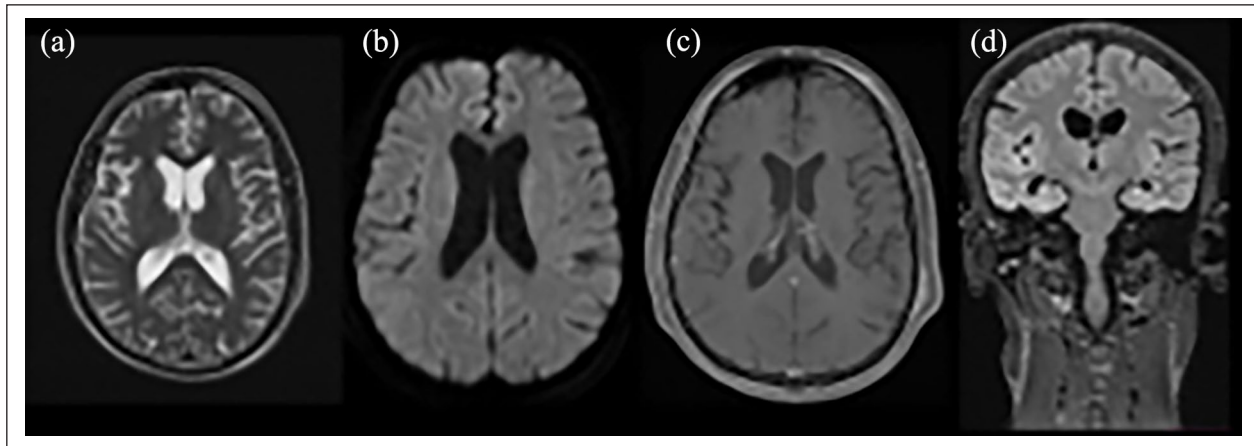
One-month follow-up magnetic resonance imaging on axial T2: (a) Diffusion-weighted imaging, (b) T1 post-gadolinium injection, (c) axial images and coronal T2 fluid-attenuated inversion recovery, and (d) image showed no abnormality.
